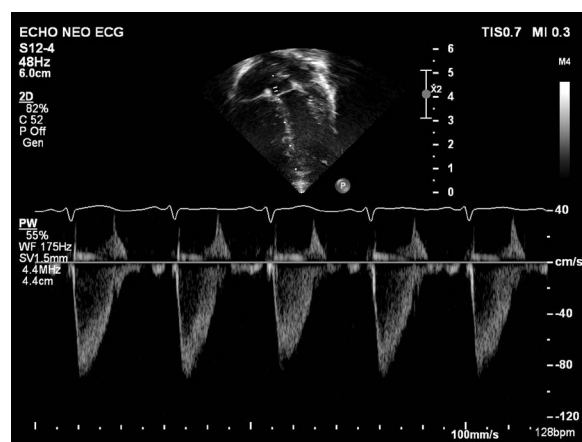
Neonatal echocardiogram presenting the sinus rhythm of the described case
